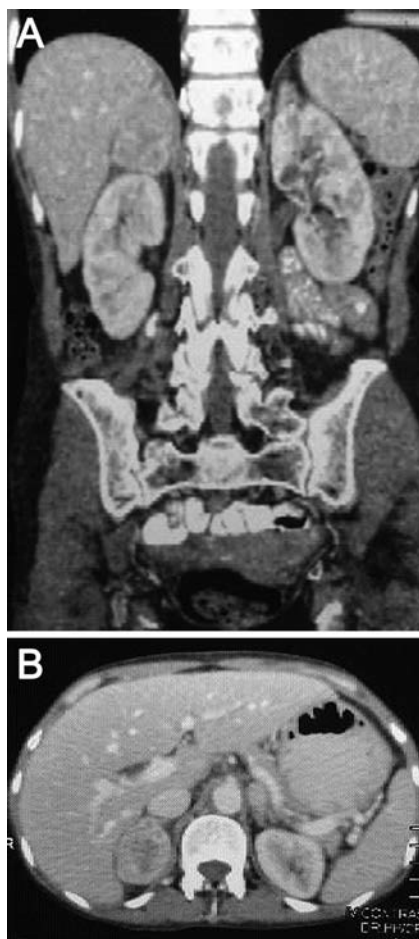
A and B) Computed tomographic images non-enhancing right adrenal gland abutting the inferior surface of the liver without calcification.
